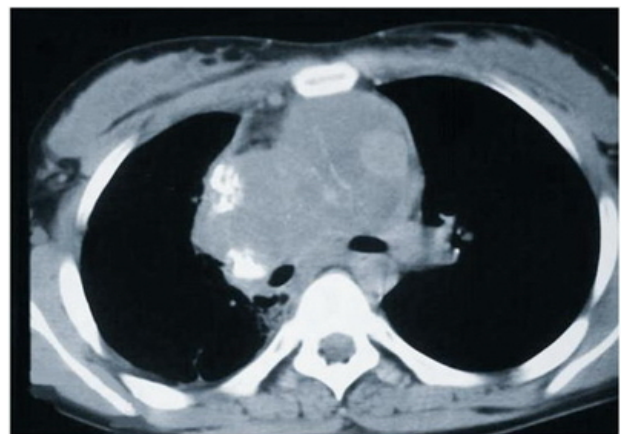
Case 4. CT scan (mediastinal window) shows large soft tissue mass in the medial part of the right upper lobe that invades in the mediastinum. Multiple irregular calcifications are noted within this mass.
